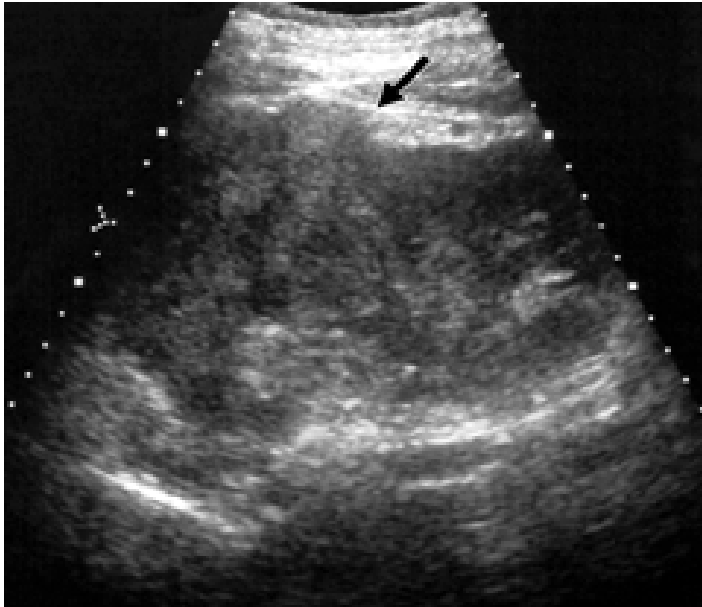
Longitudinal ultrasound image through the right kidney demonstrates a heterogenous lobulated ill-defined mass arising from the upper pole (arrow) due to renal cell carcinoma. Renal cell carcinoma [101]
